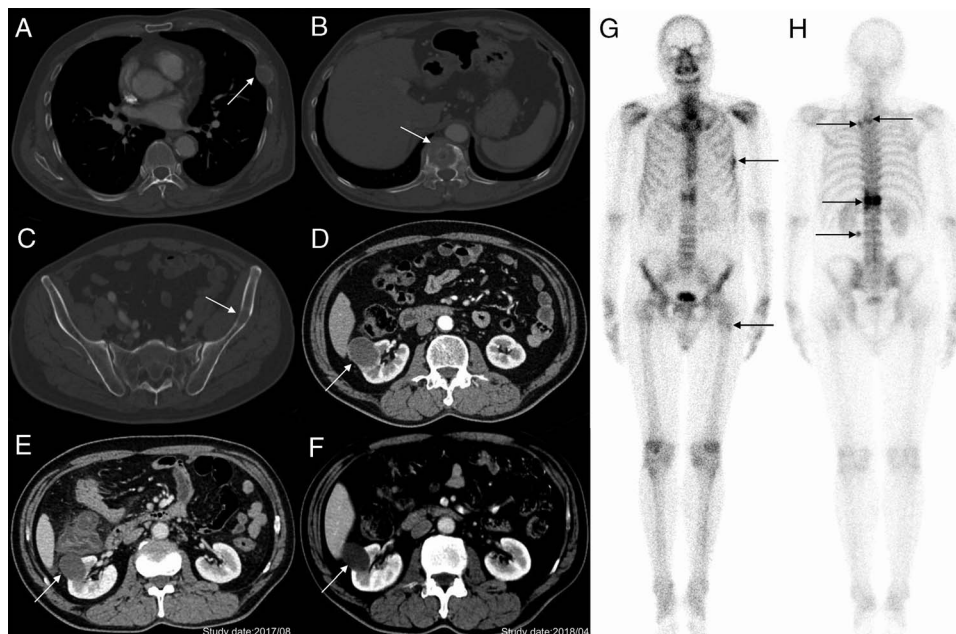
A 63-year-old man presented with a 3-month history of pain from the left shoulder and upper abdomen was admitted to our hospital. The CT image of the left sixth rib (A), thoracic vertebrae (B), and left iliac (C) showed bone destruction (arrows in A–C). The CT image (D) showed a Bosniak class IV right renal cyst (arrow). Previous images in 2017 (E) and 2018 (F) were reviewed, and CT revealed that the renal cyst was slowly enlarging from 34 mm (arrow) to 37 mm (arrow) at its greatest diameter. Because of diagnosis of bone destruction revealed by CT, ^{99m}Tc -MDP bone scan was performed to check whole-body bone condition. Anterior view (G) showed increased activity of left sixth rib and left femur (arrows). Posterior view (H) showed increased activity of second thoracic vertebrae, left transverse process of the third thoracic vertebrae, the 12th thoracic vertebrae, and left transverse process of the third lumbar vertebrae (arrows). The diagnosis of bone scan was multiple bone metastases.
